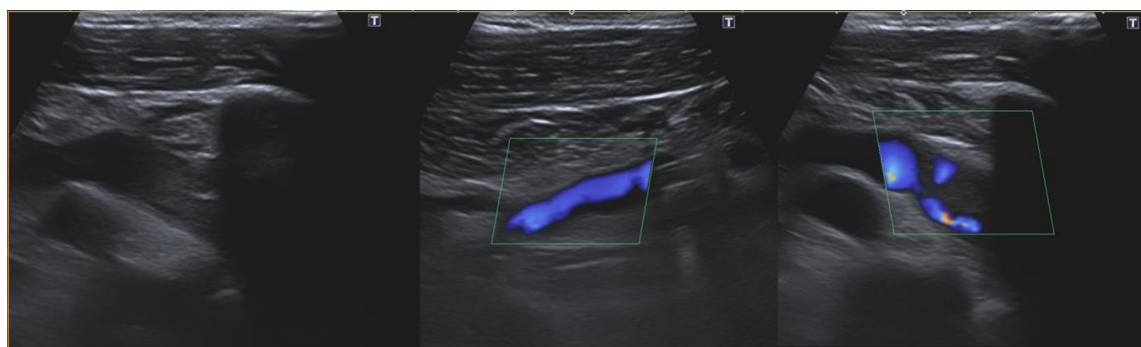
Doppler ultrasound of the right upper limb showing a thrombus in the right subclavian vein at the junction to the jugular vein
